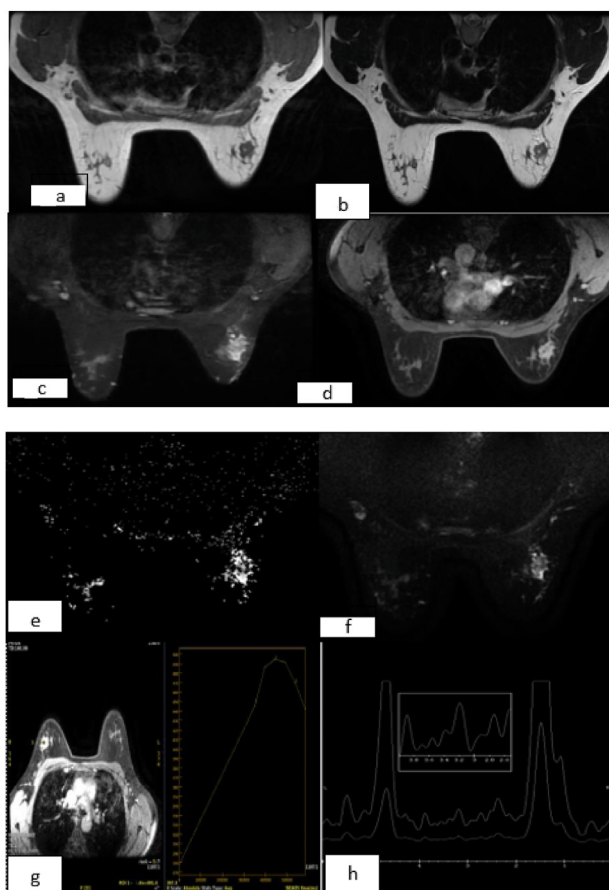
Infiltrating ductal carcinoma MRI findings an irregular lesion is detected in the upper outer quadrant of the right breast measuring (2 × 1) cm with spiculated margins. Hypointense on Axial T1WI (a), hypointense on Axial T2WI (b), hyperintense on Axial STIR (c), Homogenous enhancement (d), heterogenous diffusion restriction, mean apparent diffusion coefficient value $1.1 \times 10^{-3} \text{ mm}^2/\text{sec}$ on DWI and apparent diffusion coefficient images (e,f), Positive MRS (g), type 3 kinetic curve (h).
